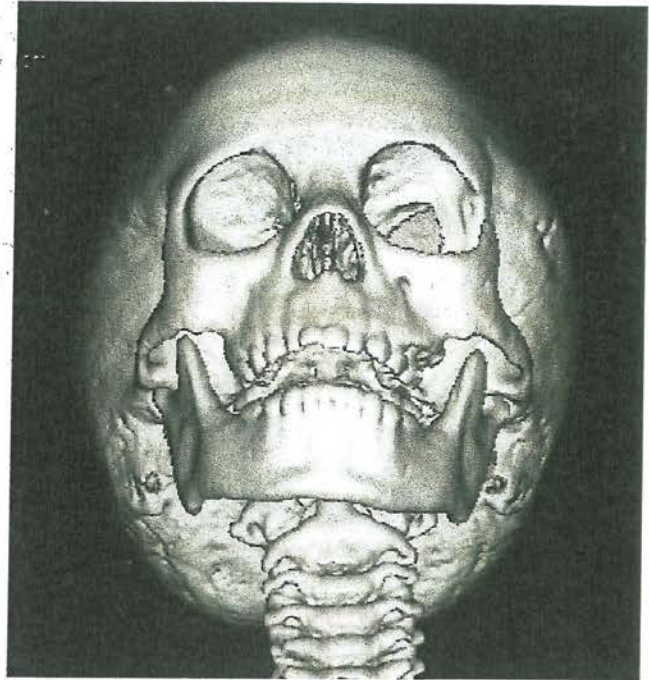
Three-dimensional CT scan showing absence of the left greater wing of the sphenoid bone
